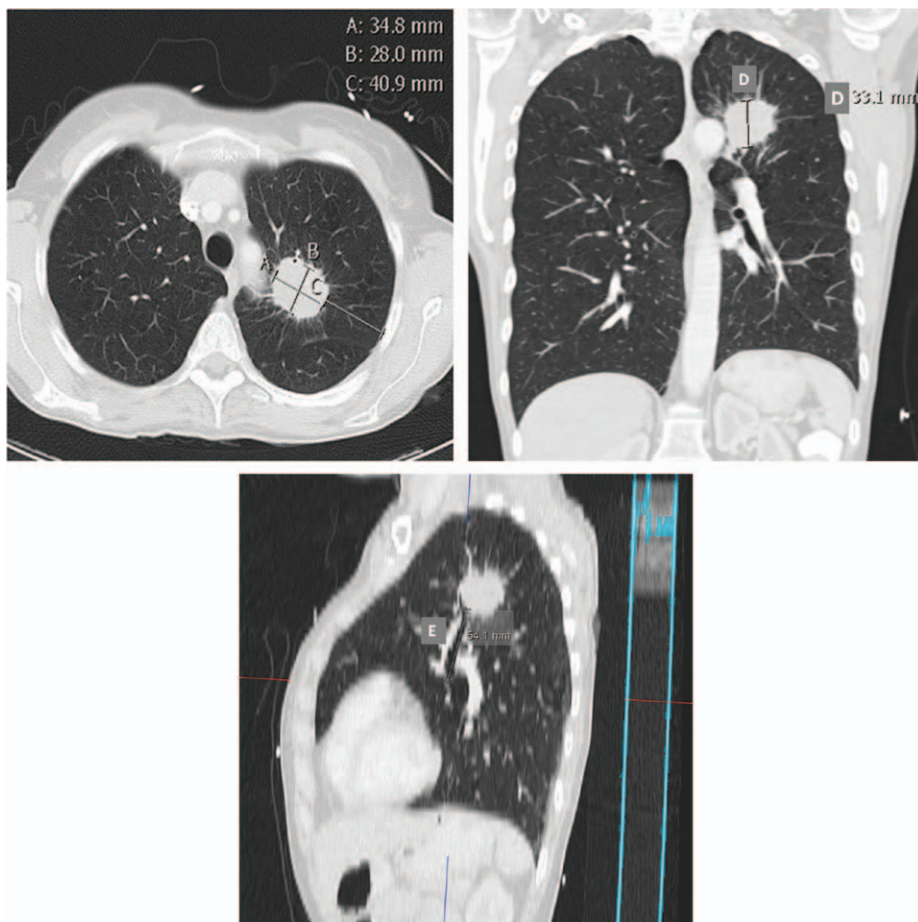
The primary tumor is located in segment 2 of the left upper lobe on computed tomography. A, The lesion was 34.8 mm in LLD and 28.0 mm in LPLD measured on axial CT images, while located 40.9 mm from the chest wall (Dthorax). B, The lesion was 33.1 mm in LAD measured on coronal CT images. C, The lesion was located 54.1 mm from the secondary carina (Dcarina) measured by volume viewing software (AGFA HealthCare NV, Mortsel, Belgium). LLD, longest lesion diameter; LPLD, longest perpendicular lesion diameter; CT, computed tomography; LAD, longest apicocaudal diameter.
